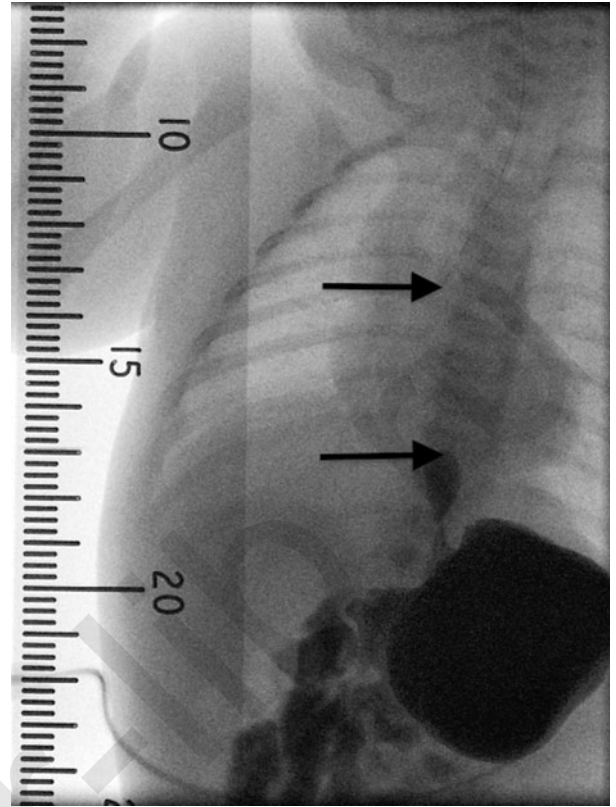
Birth defect registries and disease severity. Birth defect registries generally do not distinguish anomaly severity (despite implications for service provision and outcome measures). This gap assessment x-ray for pure esophageal atresia (EA) shows the tip of the oral tube pressed down (upper arrow) and refluxed contrast in the distal pouch (lower arrow). Treated by the author with a single-stage 'Bax' jejunal interposition at 7 weeks of age, this anomaly is registered just like the more common EA with distal fistula, despite the very different management and resources required.
